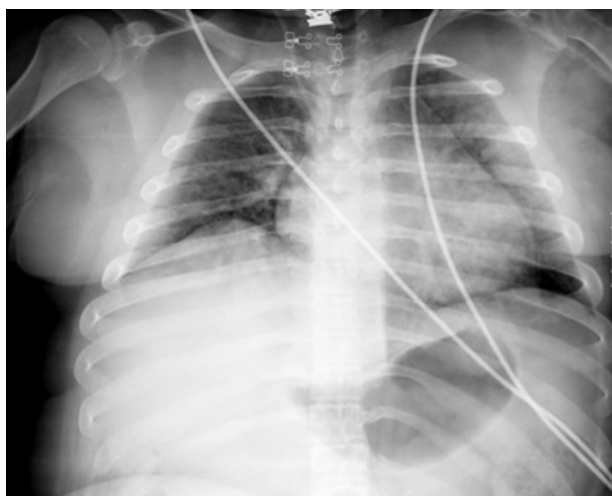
Admission X-ray showing bilateral haziness.
